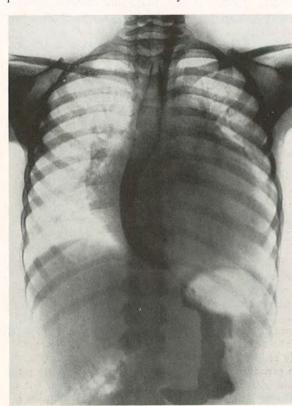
X-ray of chest about six weeks after operation and again after a swallow of barium. Although the esophagus is still deviated to the right the amount of deviation is less than before operation. It would seem, therefore, as if the simple decompression relieved somewhat the pressure of the heart on the esophagus.
